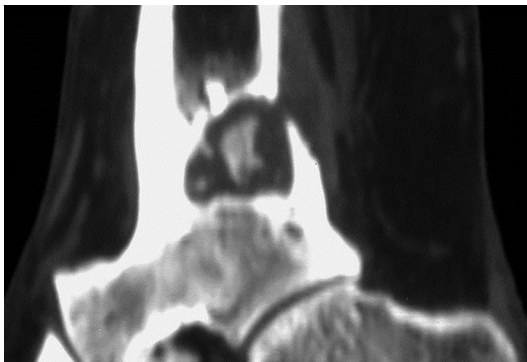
This ankle fusion was complicated by osteomyelitis. The computed tomography (CT) shows that the sequestrum lies in the central medulla but the cortical bone loss is posterior. Approaching this infection through the previous anterior incision would have removed the viable bone maintaining stability.
